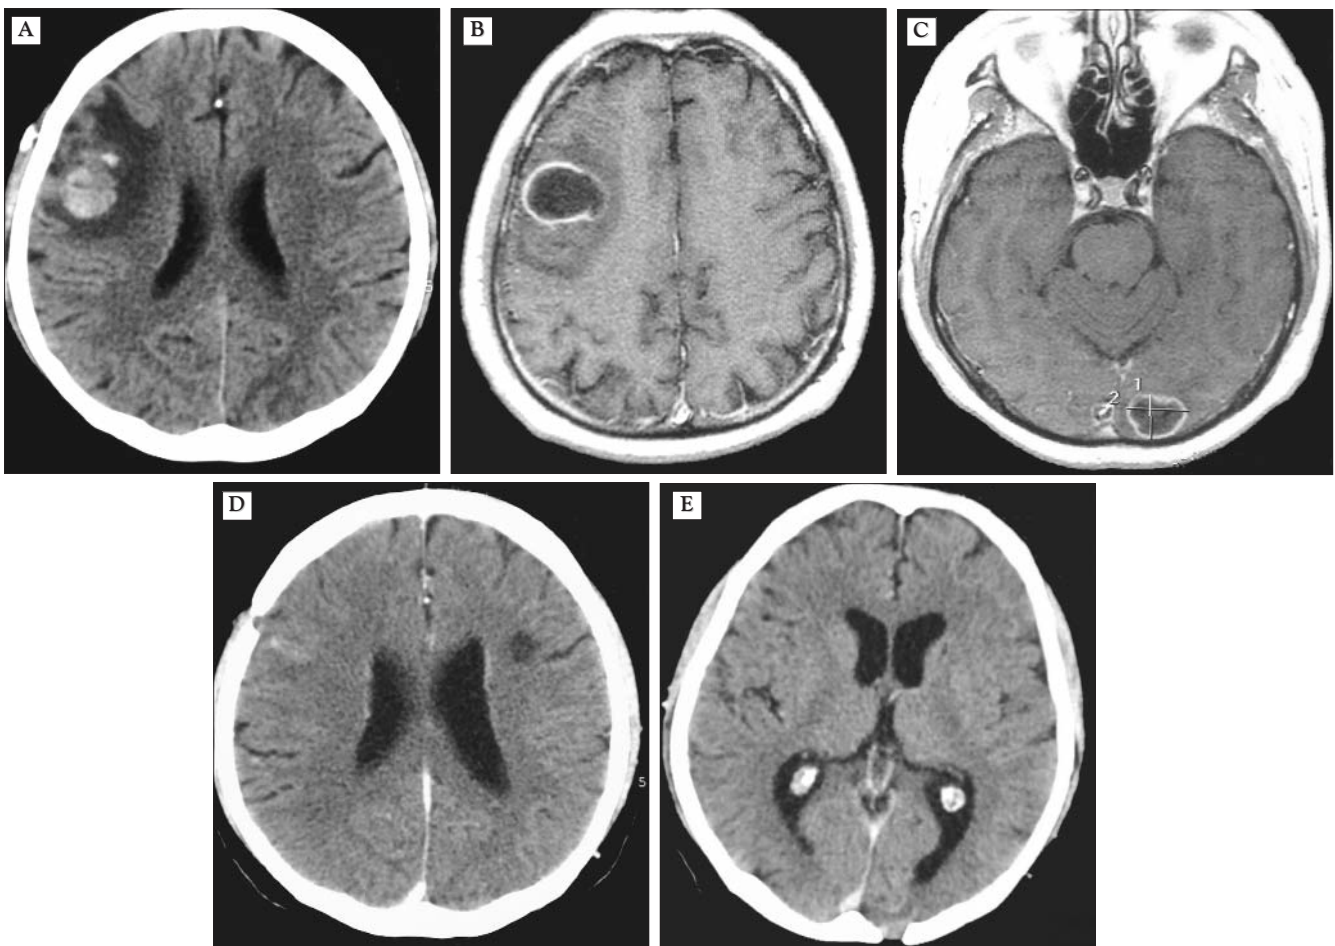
Male, 43 years old, with a six-year history of diabetes mellitus, surgically treated by stereotactic aspiration procedures for two brain abscesses localized in the right frontal lobe and in the left occipital lobe. Brain abscess cultures were positive for *Streptococcus Viridans*. (A) preoperative contrast CT scan; (B,C) preoperative axial gadolinium enhanced MRI, showing the presence of the brain abscesses; (D) 8 months and (E) 12 months postoperative contrast CT scans, showing the complete resolution of the abscesses
